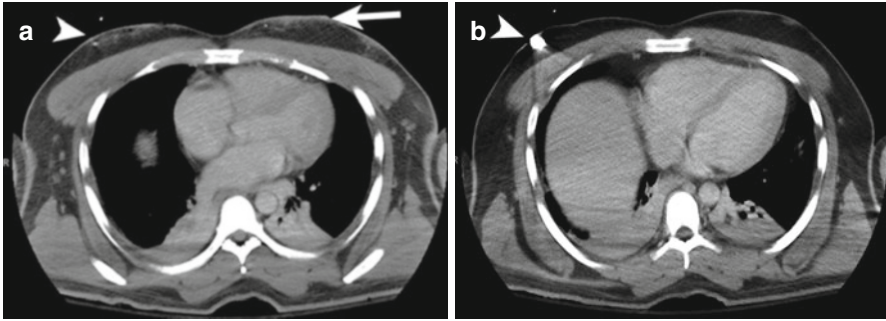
A 23 year-old male presents with pain after sustaining a gunshot wound to the upper abdomen. (a) Post contrast computed tomography (CT) shows the tract of the bullet; the bullet entered the subcutaneous tissues in the left upper quadrant (*arrow*) and traveled tangentially to the right upper quadrant (*arrowhead*) without traversing the fascial layer. (b) Immediately inferiorly, the bullet (*arrowhead*) is lodged in the subcutaneous tissues of the right upper quadrant
